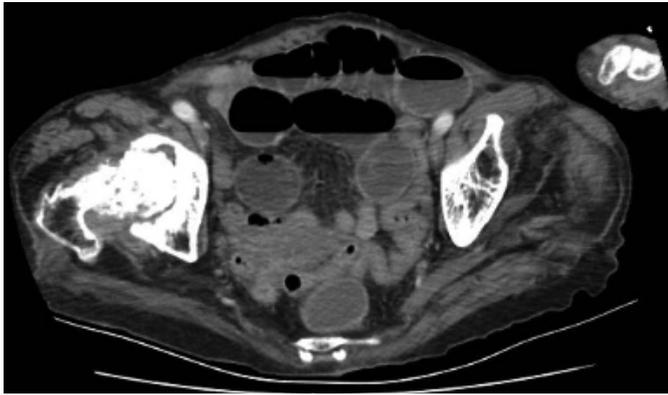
A radiologic image; transverse view, demonstrating a right-sided obstructive obturator hernia (Computed tomography scan; Transverse view).
